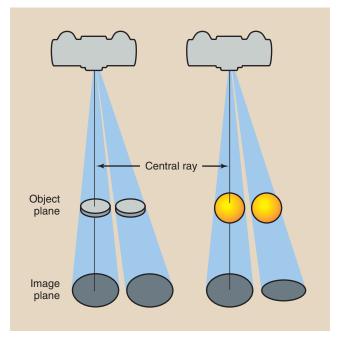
Object thickness influences distortion. Radiographs of a disc or sphere appear as circles if the object is on the central ray. When lateral to the central axis, the disc appears as a circle and the sphere as an ellipse.
